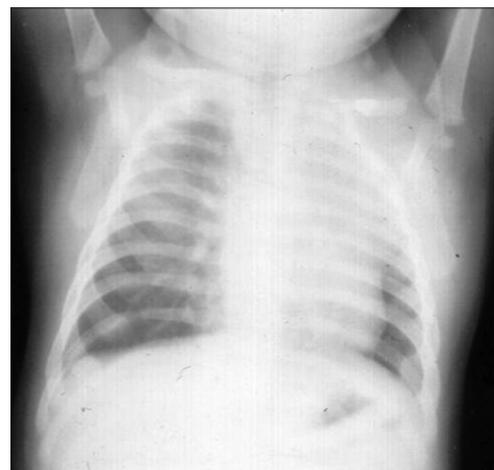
Ches X-ray of Case number 5.
